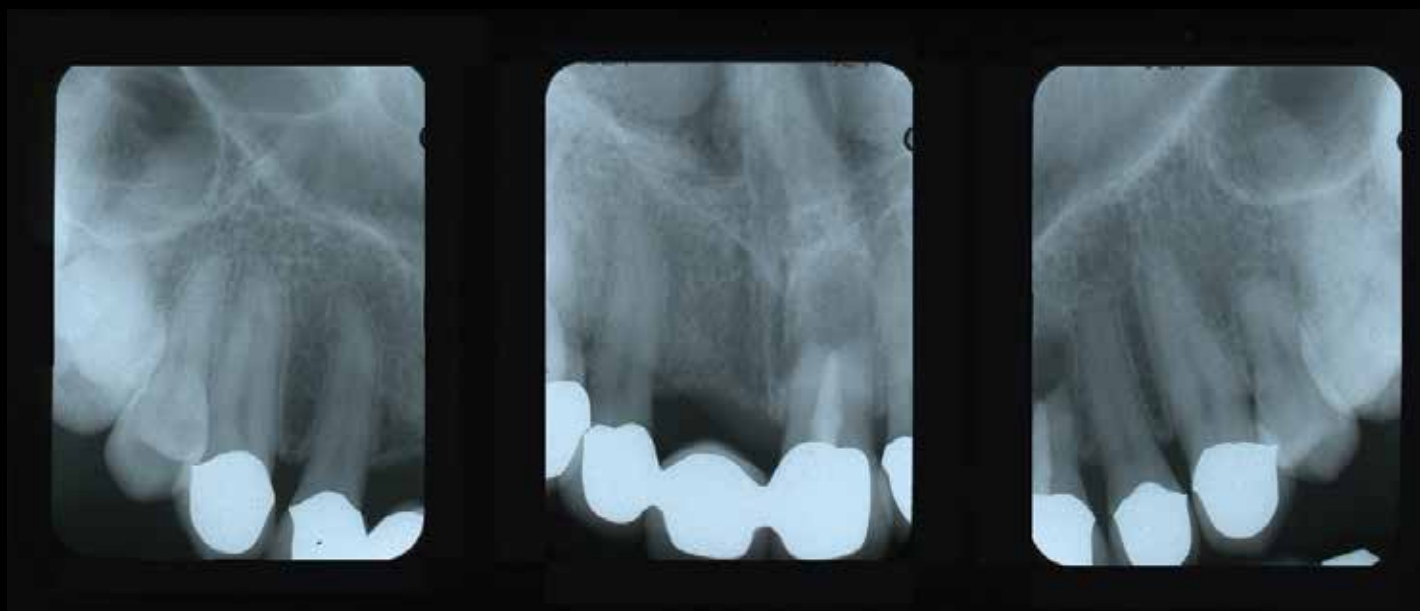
The patient had a history of trauma to the six anterior maxillary teeth. Although they were asymptomatic, a preoperative radiograph demonstrated an endodontic treatment on #9 with a history of periapical surgery.
